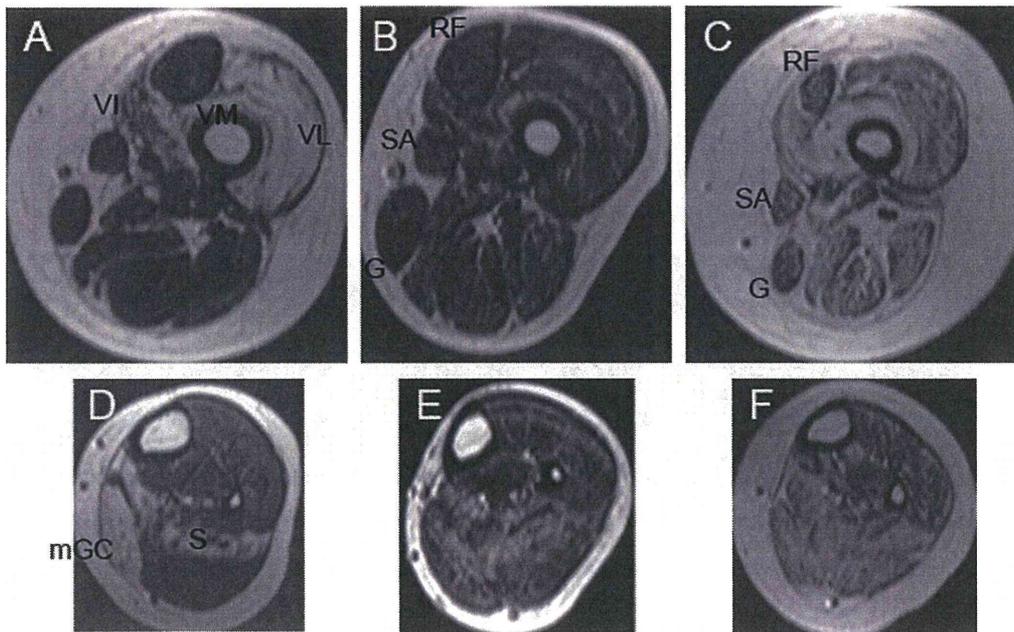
Selective muscle involvement of thigh and calf muscles. Transverse sections of T1 weighted magnetic resonance imaging of thigh (A–C) and calf (D–F) in patients with *LMNA* mutations. Selective involvements of vastus lateralis (VL), vastus intermedius (VI), vastus medialis (VM), soleus (S), and medial head of gastrocnemius (mGC, A, D: Patient 1), relatively mild and diffuse involvements with relative sparing of rectus femoris (RF), gracilis (G), sartorius (SA, B, E: patient 11), and diffuse and severe involvement with relative sparing of rectus femoris, gracilis, sartorius (C, F: patient 9) are observed.
